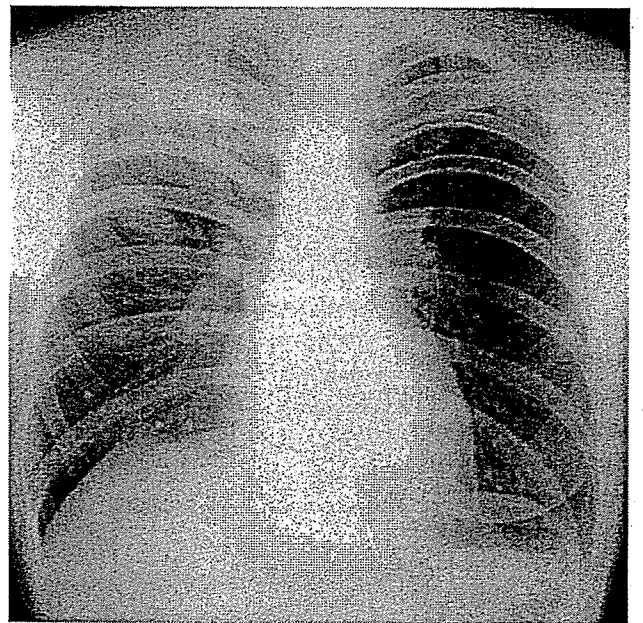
Eight months after irradiation, chest X-ray showed a new shadow in the upper field of the ipsilateral lung.
